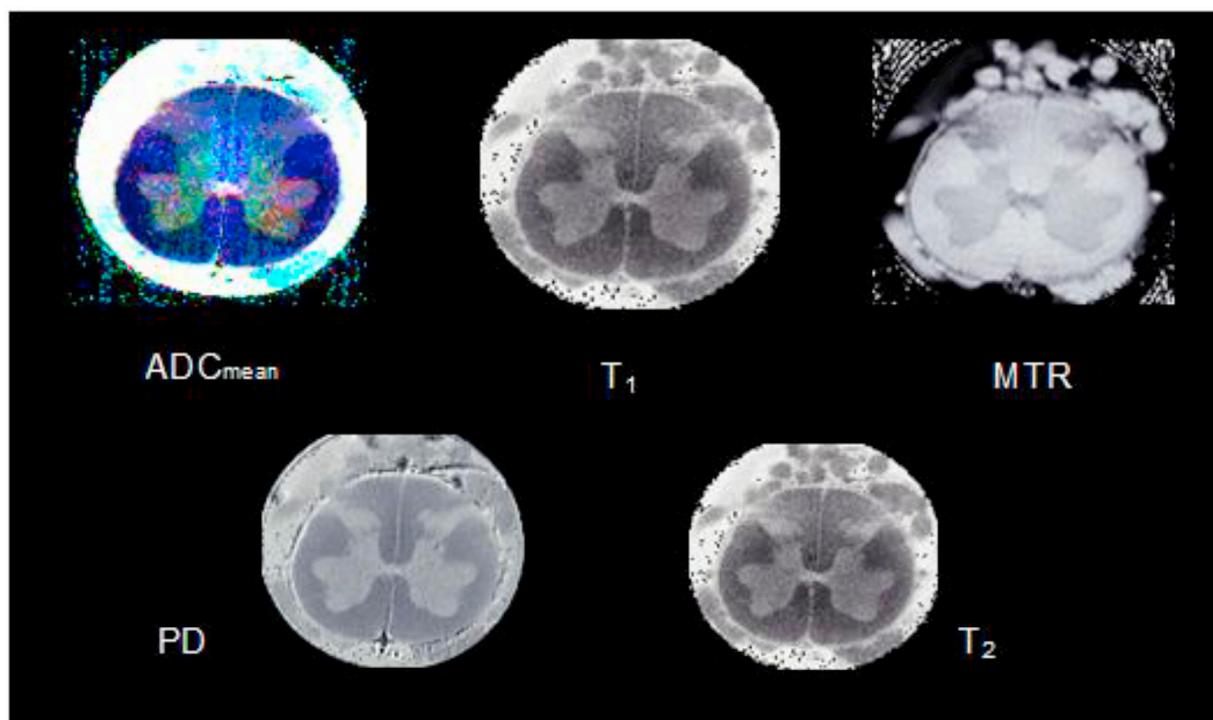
MRI measures in lumbar spinal cord of a healthy subject (ADC mean = mean apparent diffusion coefficient). Reproduced from (Mottershead et al., 2003) with permission.
